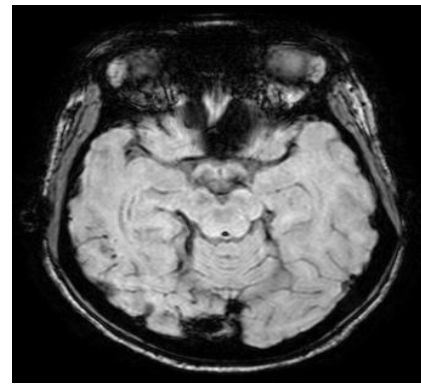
A&B: - SWI and DWI showing haemorrhagic infarcts in the right frontal and parietal lobes. C&D: MRV shows loss of normal flow voids with filling defects in post contrast images in superior sagittal, right transverse, sigmoid sinuses, internal jugular vein and distal straight sinuses.
